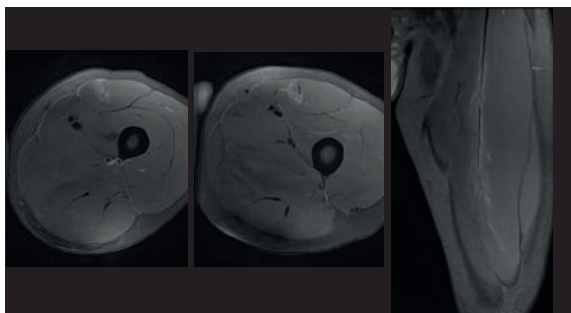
(Case #6). MTJ strain of the central septum of anterior rectus femoris muscle. MRI signs include peritendinous oedema, tendinous mixed disruption, minimal intermuscular fluid/haemorrhage, and mild loss of septum tension.
